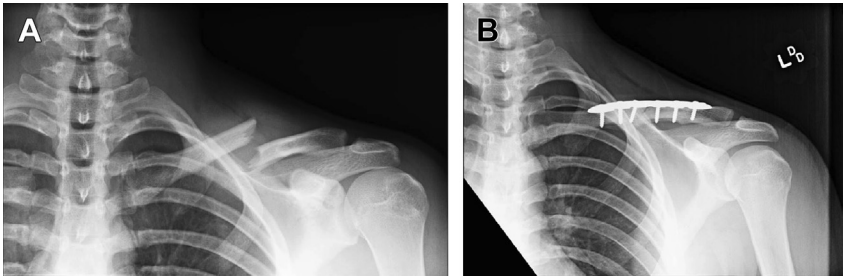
(A) A 17-year-old boy with left clavicle fracture from football. Radiographs show a 100% displaced and minimally shortened fracture. After discussion with family, he elected operative fixation. (B) Appearance of clavicle fracture 3 months after plate fixation.
